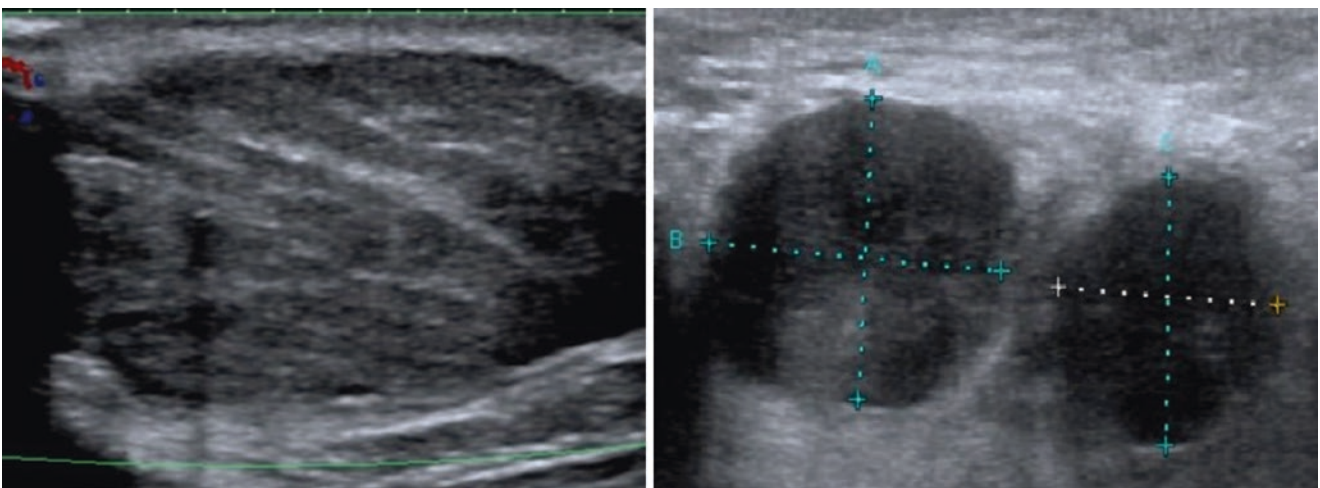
Girl, aged 15 years, with a left hand intramuscular mass and homolateral axillary lymphadenopathies on ultrasound examination corresponding to an alveolar rhabdomyosarcoma
